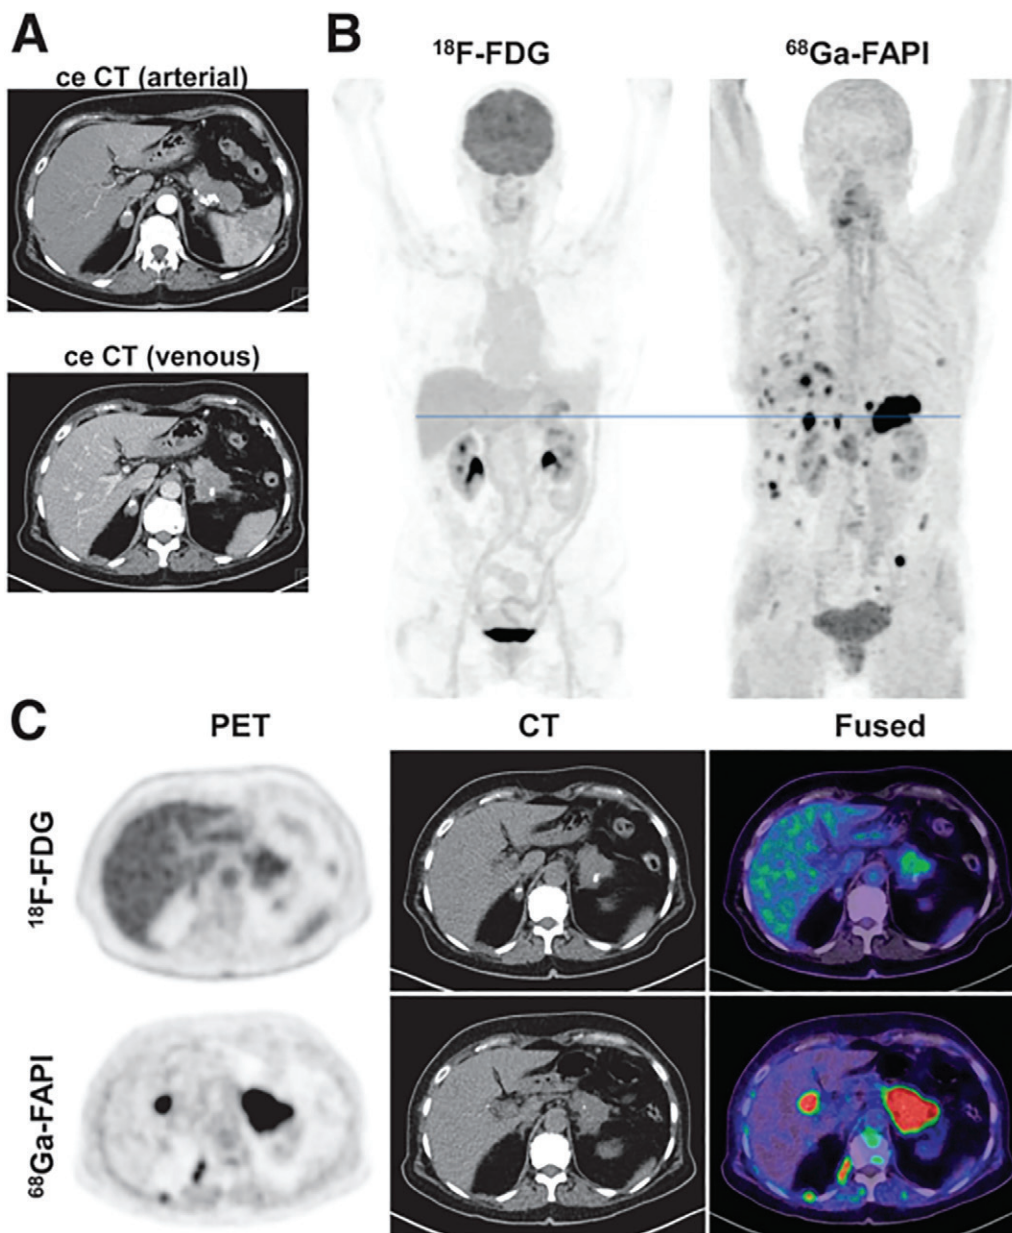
Images obtained for primary staging in a 58-year-old man with pancreatic ductal adenocarcinoma. (A) Axial contrast-enhanced (ce) CT images of pancreatic ductal adenocarcinoma and liver in arterial (upper image) and venous (lower image) phase. (B) Mean intensity projection images from fluorine 18 (^{18}F) fluorodeoxyglucose (FDG) (left) and gallium 68 (^{68}Ga) fibroblast-activation protein inhibitor (FAPI) (right) PET/CT. (C) Axial fused ^{18}F -FDG CT image (upper row, right image) and FAPI PET/CT image (lower row, right image) in the same patient at the level (blue line in B) of the pancreatic tumor mass and another suspicious FAPI accumulation in projection on perihepatic lymph node (corresponding CT scans, middle images). A metastatic situation, which had been revealed with FAPI PET/CT, was confirmed with biopsy of pulmonary lesion that was diagnosed as metastasis of known pancreatic ductal adenocarcinoma. (Adapted, under a CC BY license, from reference 53.)
